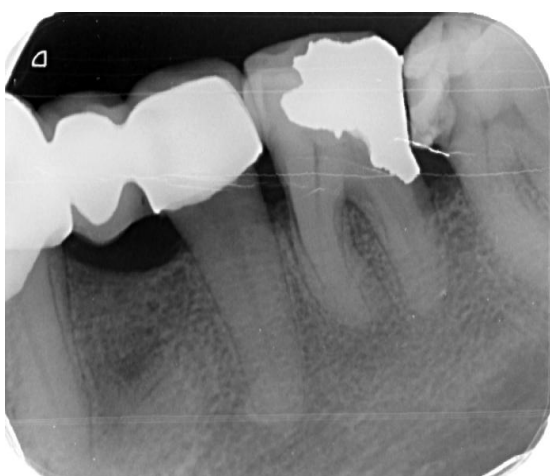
Postoperative radiograph showing the healing of bone defect 3 months after surgery
